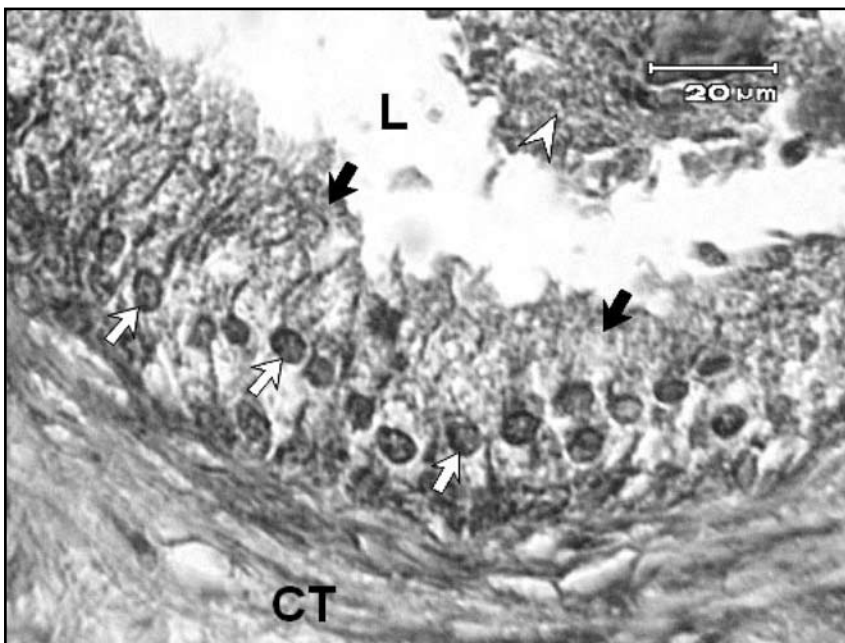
Photograph of benign prostatic hyperplasia of human prostate gland after treatment with anti-ubiquitin. Portion of prostatic acinus is shown. Intense immunoreactivity is shown in the nuclei of lining epithelium (white arrows) while the cytoplasm shows mild reaction for ubiquitin (black arrows). Secretory products (arrow head) in the lumen of the acinus (L) show mild reaction. Fibromuscular compartment of the connective tissue (CT) shows positive reaction for ubiquitin.
